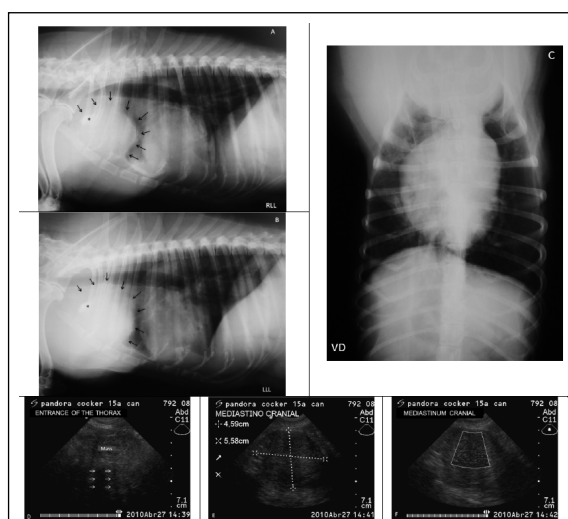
Radiographic and ultrasound examinations of a 15-year-old female Cocker. Radiographic examination (Figures 3A, B and C) shows a mass measuring approximately 6 cm in diameter (arrows) in the region of the sternal lymph node. There is an area of focal calcification (*) in the mass. The B-mode ultrasound examination (Figure D), viewed from the entrance of the thorax, demonstrates a mass with heterogeneous echogenicity and echotexture. The mass has irregular borders and is in the area of the sternal lymph nodes, demonstrates calcifications dispersed throughout the tissue and forms an acoustic shadow (white arrows). The same mass is visualized at the lateral edge of the thorax (Figure E). Power Doppler evaluation shows a mottled central vascularization pattern (Figure F).
